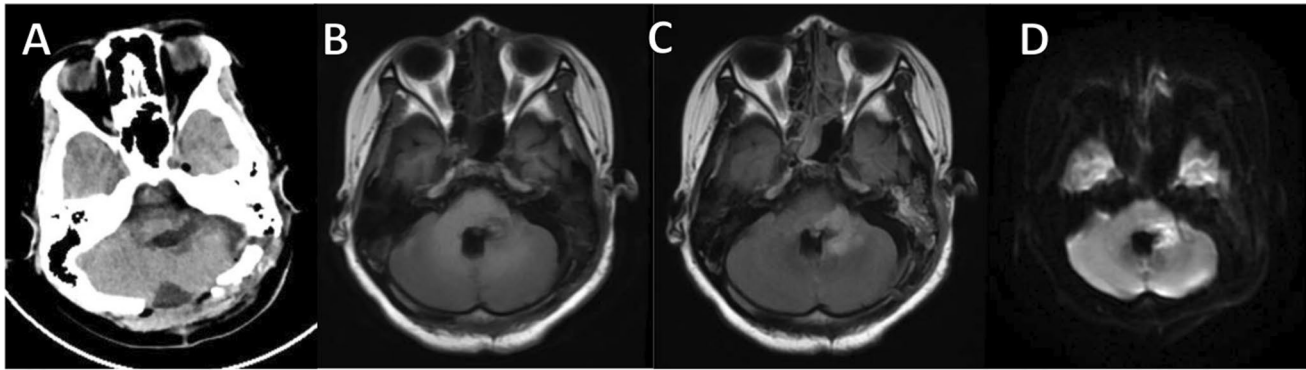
Postoperative CT (A), MRI-T1 (B), MRI-T2 FLAIR (C), and DWI (D)
